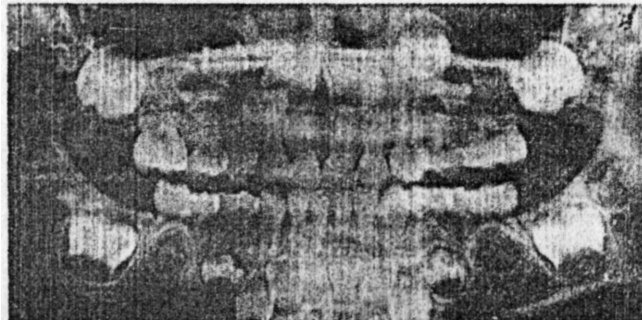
Orthopantomograph showing the state of the dentition at four years of age.
